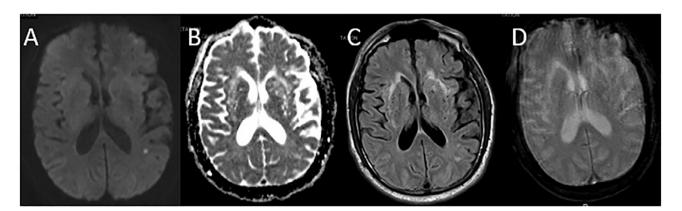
Brain MRI, axial cuts. Images obtained hospital day 24 from initial hospitalization. (A) Diffusion-weighted imaging (DWI) and (B) apparent diffusion coefficient (ADC) sequences show small area of restricted diffusion in left parietal lobe. (C) Fluid attenuated inversion recovery (FLAIR) sequence demonstrates T2 hyperintensities in deep white matter. (D) Gradient echo sequence is without evidence of microhemorrhages.
